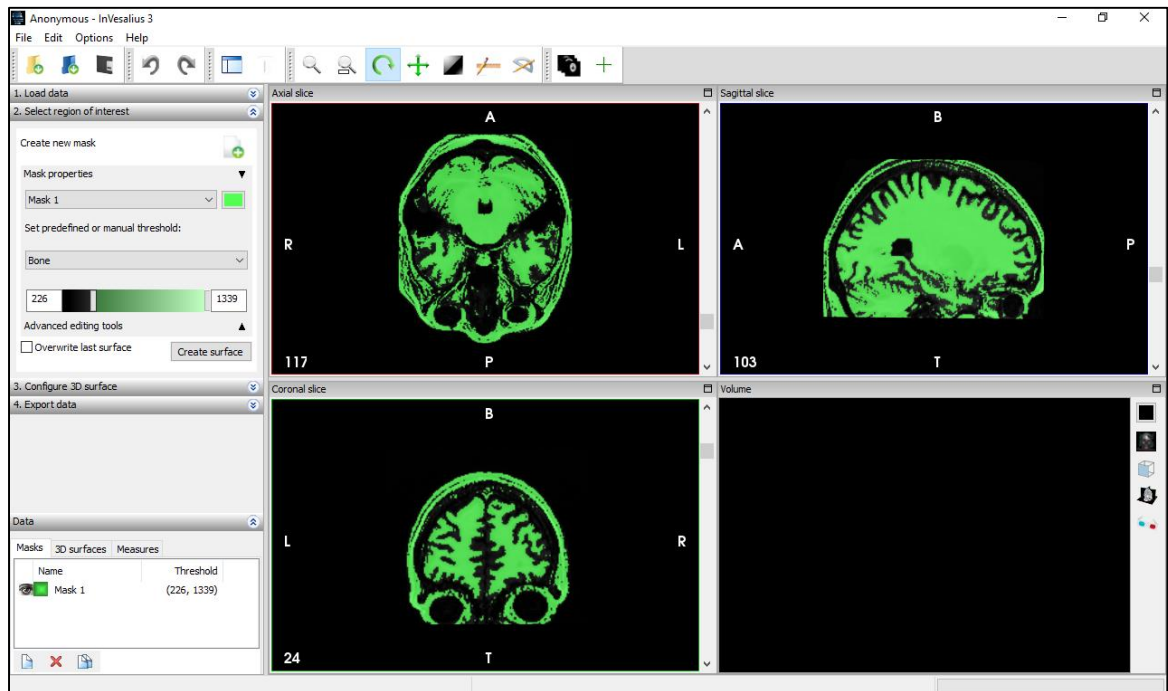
InVesalius software with 3D images from the MRI scan.
